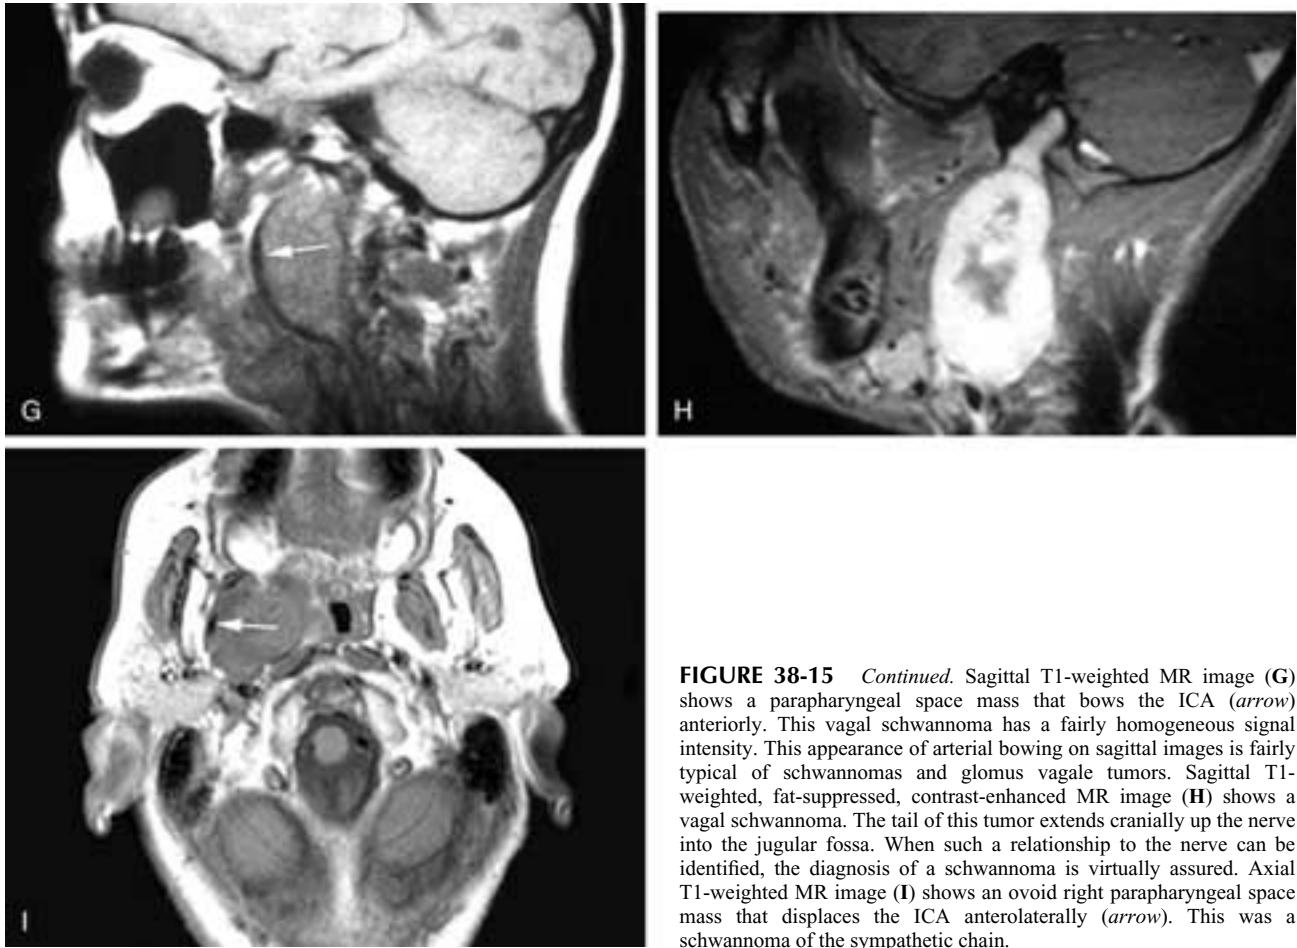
Continued.* Sagittal T1-weighted MR image (G) shows a parapharyngeal space mass that bows the ICA (arrow) anteriorly. This vagal schwannoma has a fairly homogeneous signal intensity. This appearance of arterial bowing on sagittal images is fairly typical of schwannomas and glomus vagale tumors. Sagittal T1-weighted, fat-suppressed, contrast-enhanced MR image (H) shows a vagal schwannoma. The tail of this tumor extends cranially up the nerve into the jugular fossa. When such a relationship to the nerve can be identified, the diagnosis of a schwannoma is virtually assured. Axial T1-weighted MR image (I) shows an ovoid right parapharyngeal space mass that displaces the ICA anterolaterally (arrow). This was a schwannoma of the sympathetic chain.
